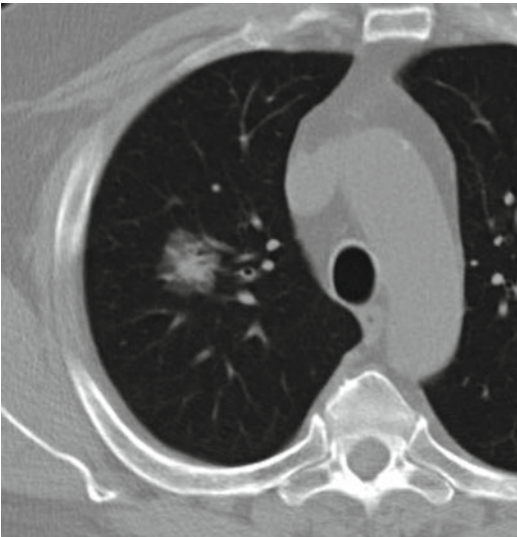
Axial CT image reveals part-solid nodule with solid core and peripheral ground-glass opacity. Appearance is typical of invasive adenocarcinoma
